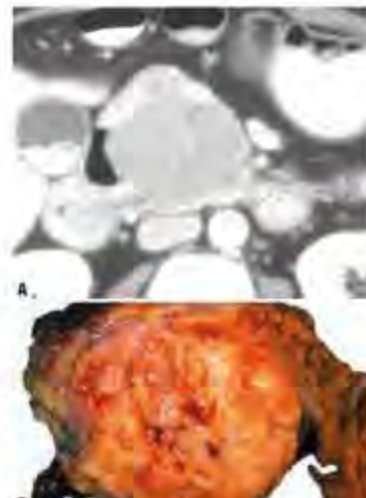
Pancreatoblastoma. A CT of a pancreatoblastoma in the head of the pancreas. B The cut surface of the neoplasm shows the lobulated surface.
